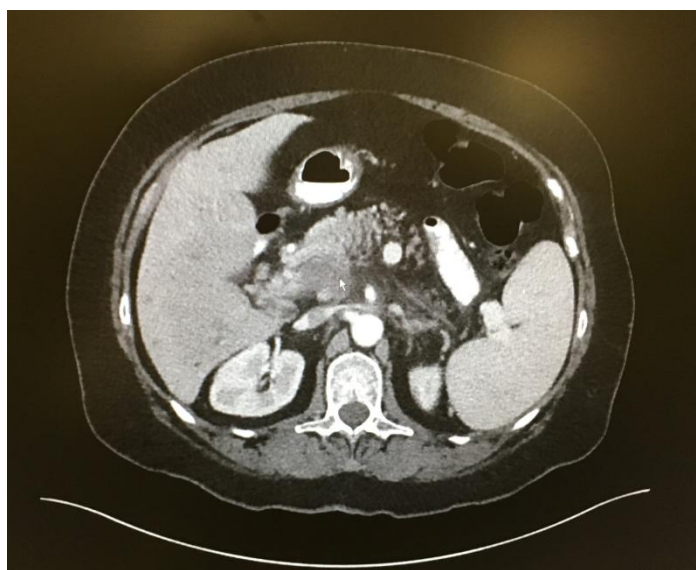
Abdominal CT revealing a mass on the dorsal aspect of the pancreatic head
